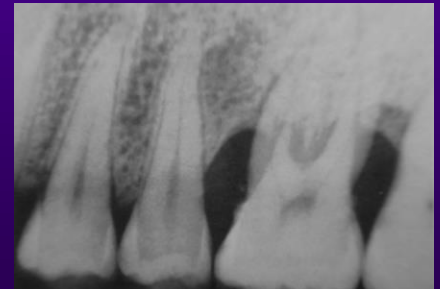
This periapical image shows an extended radiolucency from the alveolar crest to the periapical region of tooth 46. This points towards the presence of periodontal and periapical inflammatory pathologies (perio-endo lesion).
